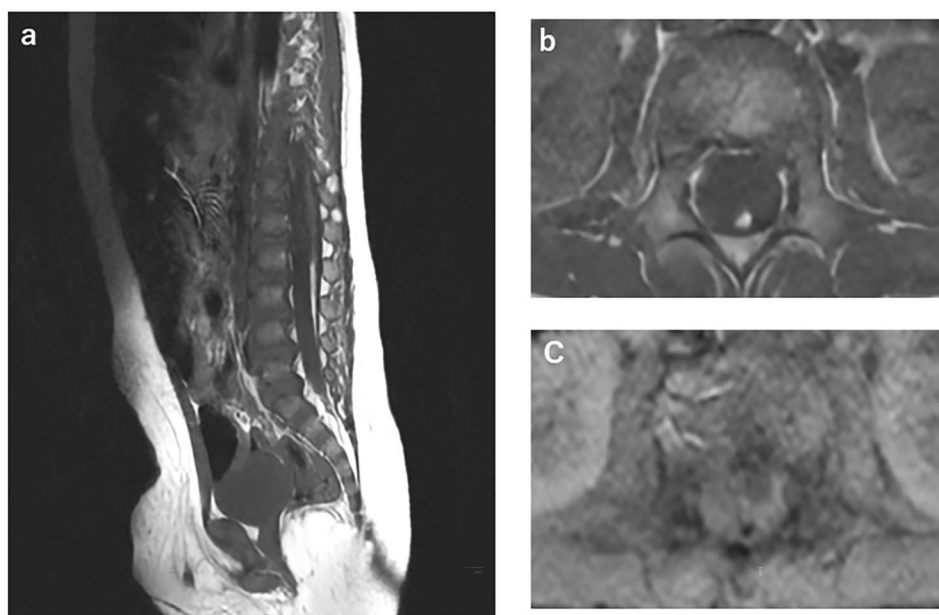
Preoperative MRI showed a T1 hyperintense fatty filum. a: sagittal T1-weighted image. b: axial T1-weighted image. c: signal suppression on fat T1 saturated sequence
